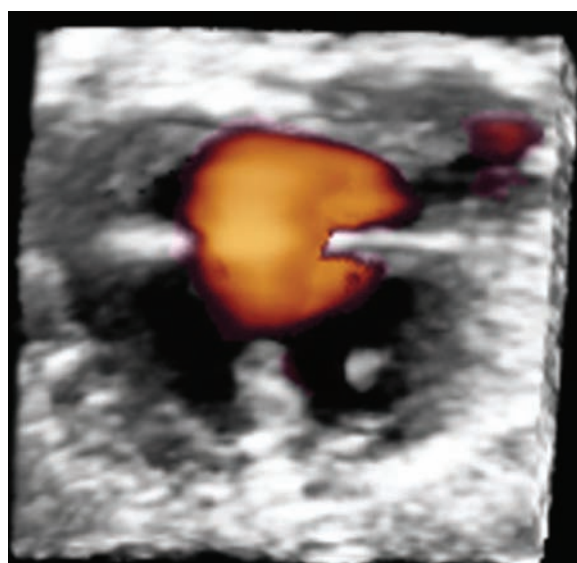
Glass body rendering (surface-rendered image) of an AV canal (23 weeks). The combination of transparent mode and power Doppler displays the defect in the valvular plane.
